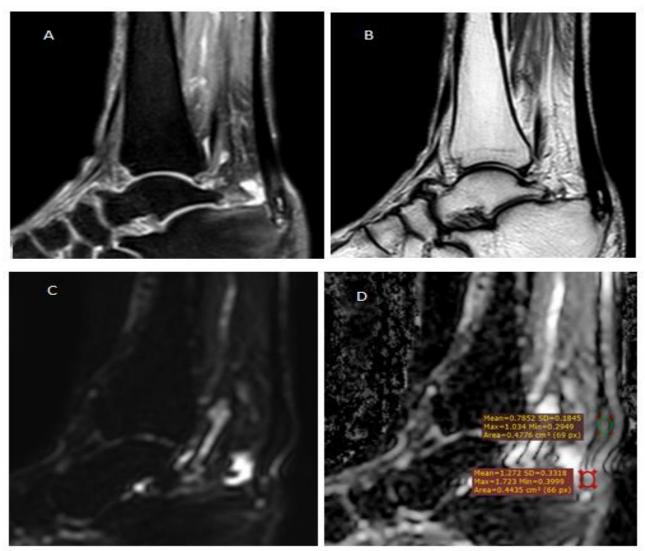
29 year old male patient presented with posterior ankle pain associated with swelling and difficult walking, Image A (Sagittal PDWI fat-sat) and B (Sagittal T2WI) showing thickening and abnormal intrasubstance high signal intensity along its length along with another focal area of abnormal increased signal intensity at its insertion site displaying high SI at PDWI and T2WI, with partial loss of the fibrillar continuity, associated retro-calcaneal bursitis and postero-superior calcaneal exostosis. Image C (Sagittal DWI) showing thickening
